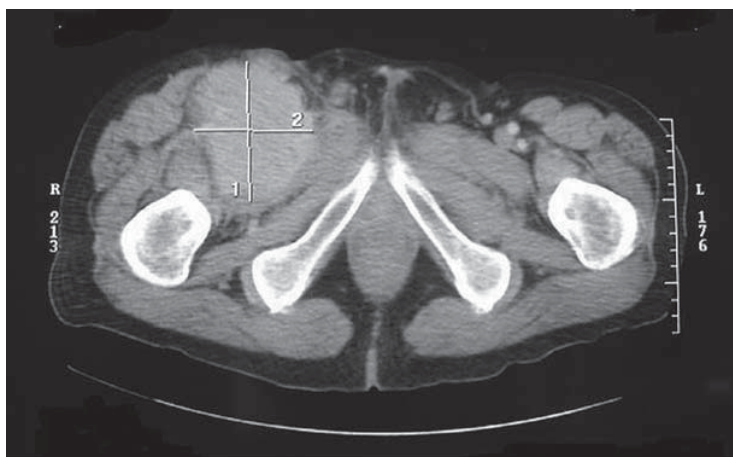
Axial CT of the pelvis showing a lymph node in the right inguinal region
